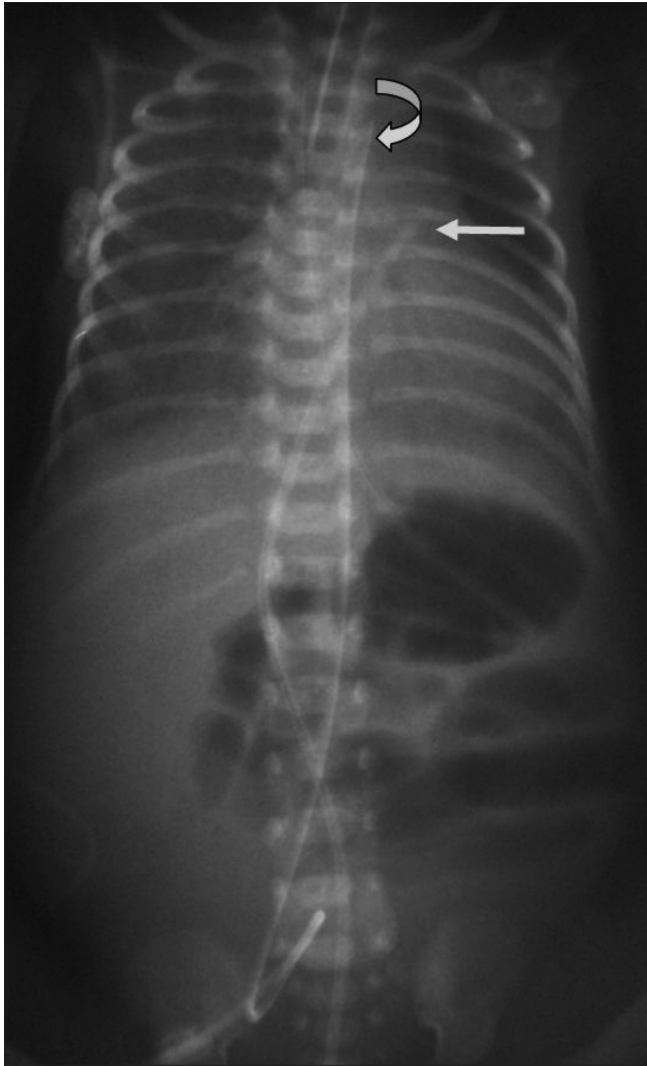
Frontal radiograph of the chest and abdomen of a neonate shows the tip of an umbilical venous catheter (straight arrow) in the left atrium; it has passed through a patent foramen ovale. The tip of the umbilical artery catheter (curved arrow) is in the arch of the aorta (which is undesirable as it is near the origin of the carotid artery)
